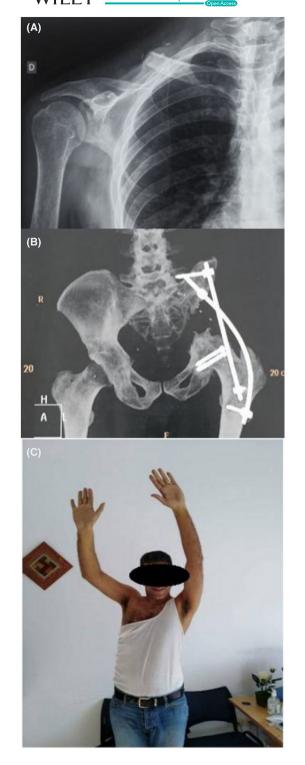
X-ray of the shoulder (A) and of the pelvis (B) and clinical result (C) after 4 years of follow-up.
